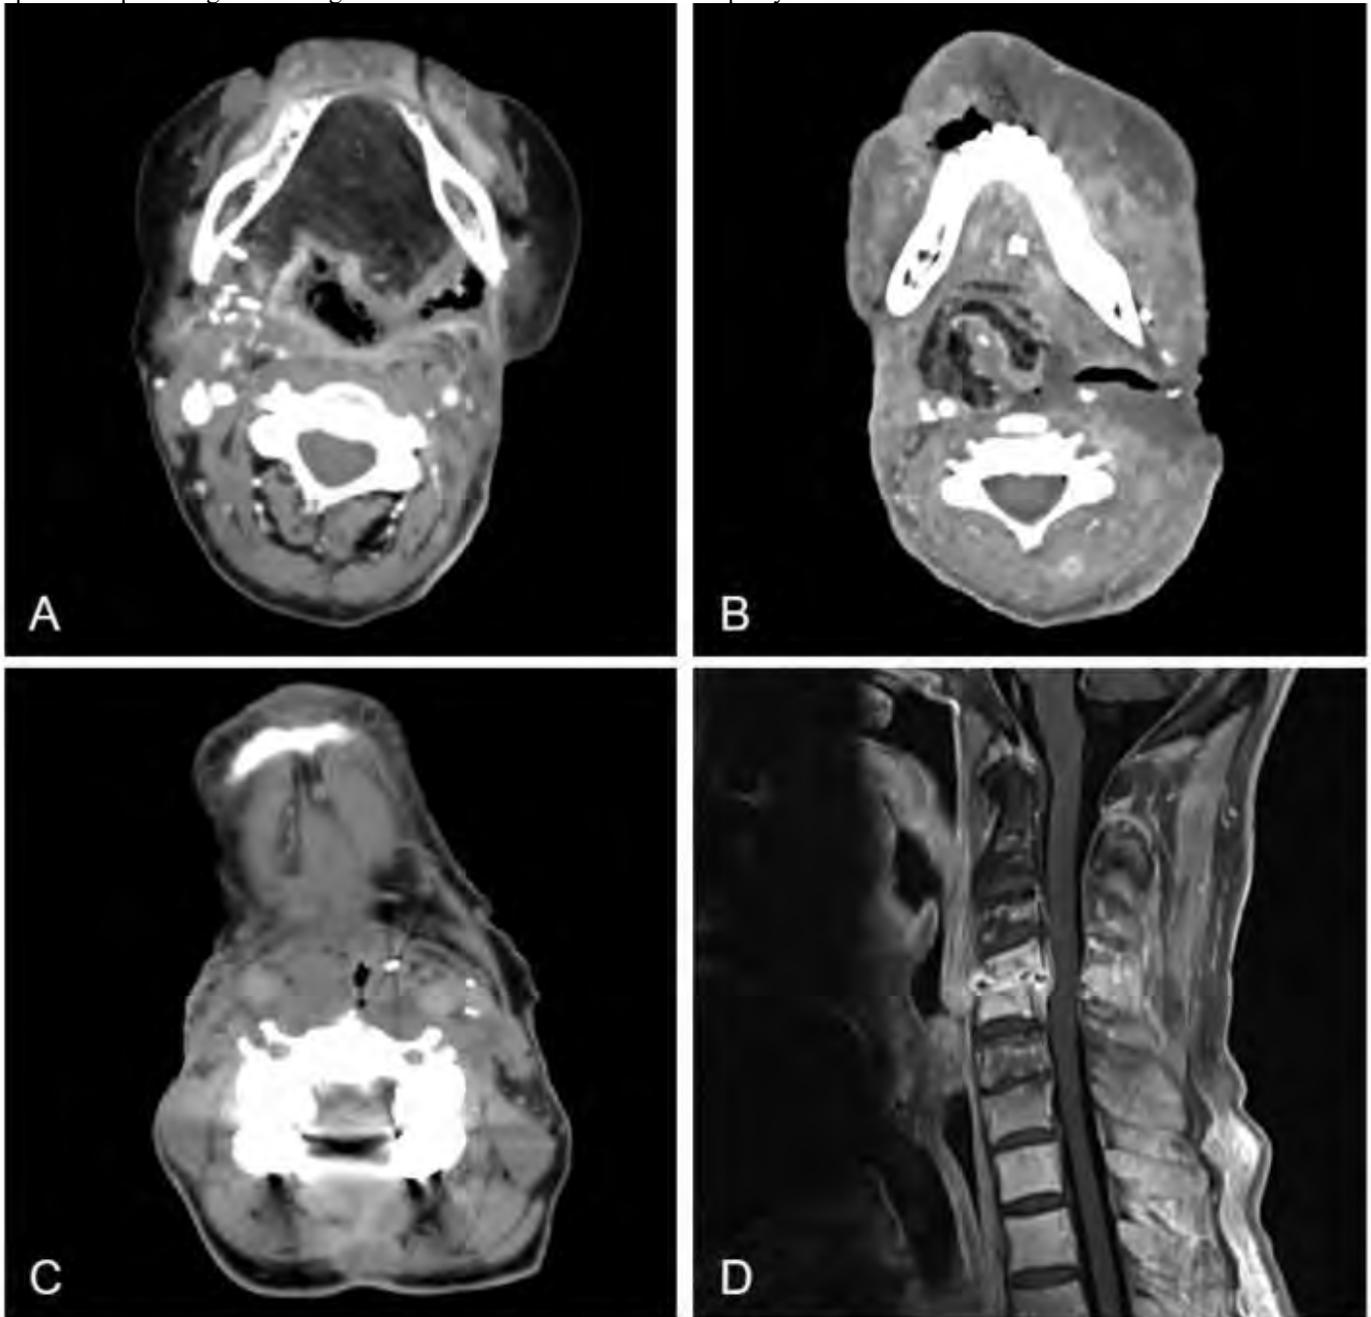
Imaging appearance of neopharyngeal fistulae and related complications. (A) Neopharyngocutaneous fistula extending to the lateral left neck. (B) Exposed left common carotid artery coursing through a fluid/air-filled neopharyngocutaneous fistula, with luminal irregularity concerning for mural thrombus and injury. (C) Air-filled fistulous tract from the neopharynx to the prevertebral space with extensive retropharyngeal/prevertebral edema. (D) Corresponding post-contrast sagittal T1-weighted MRI shows associated C4-5 discitis-osteomyelitis.
